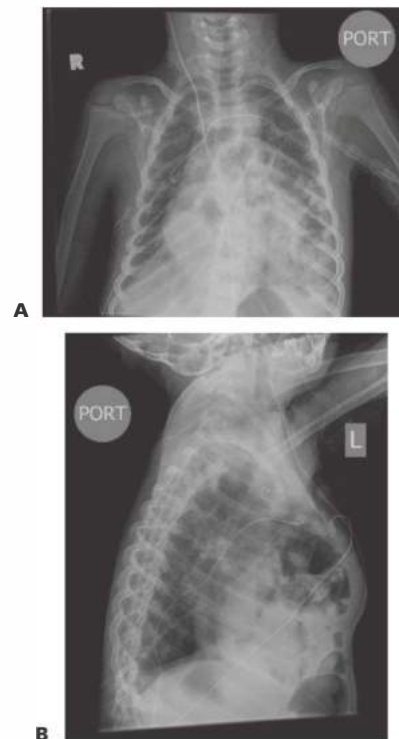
• PA (A) and lateral (B) chest x-ray demonstrating air-filled loops of bowel in the anterior mediastinum consistent with a Morgagni diaphragmatic hernia.
